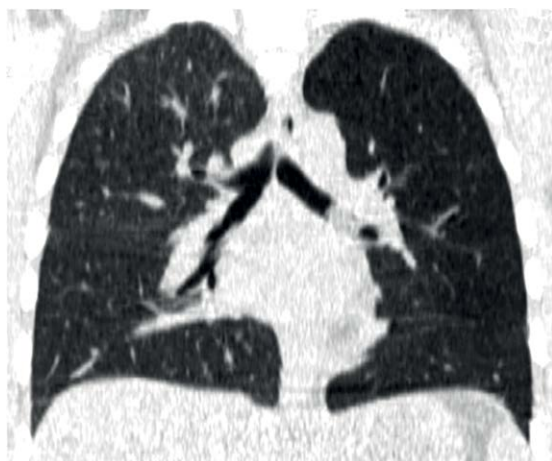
Chest CT scan with coronal reconstruction showing diffuse hypoattenuation in the left lung. Also note the opacity with soft-tissue density within the left main bronchus.
